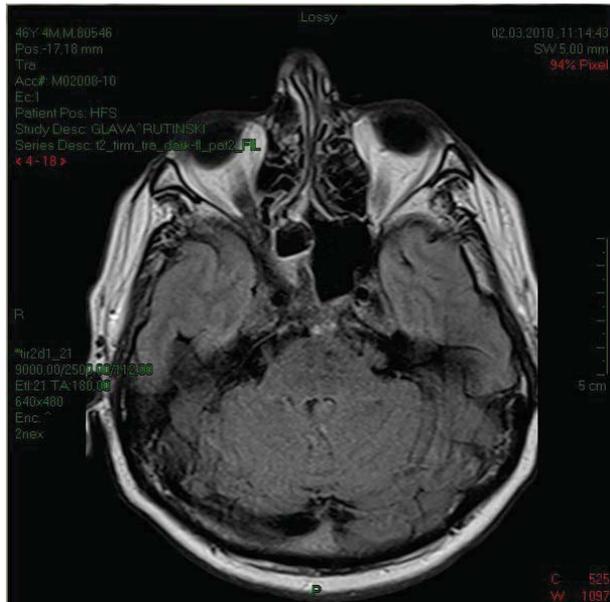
Magnetic resonance imaging (MRI) scan in March 2010 (7 months later following corticosteroid treatment)
